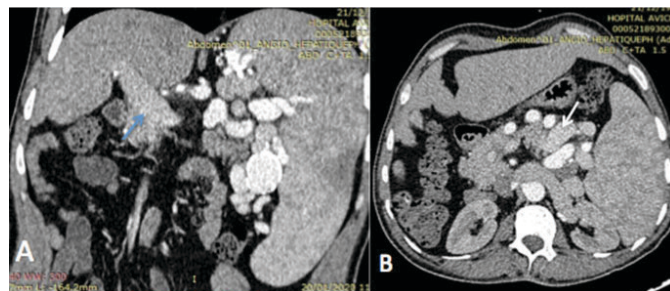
CTA at arterial phase with concomitant enhancement of the enlarged splenic vein (white arrow) and venous collateral vessels, without significant enhancement of the spleen, indicating an arteriovenous anastomosis in the splenic hilum. There is evidence of portal hypertension, with an enlarged portal vein (blue arrow) and a splenomegaly.
